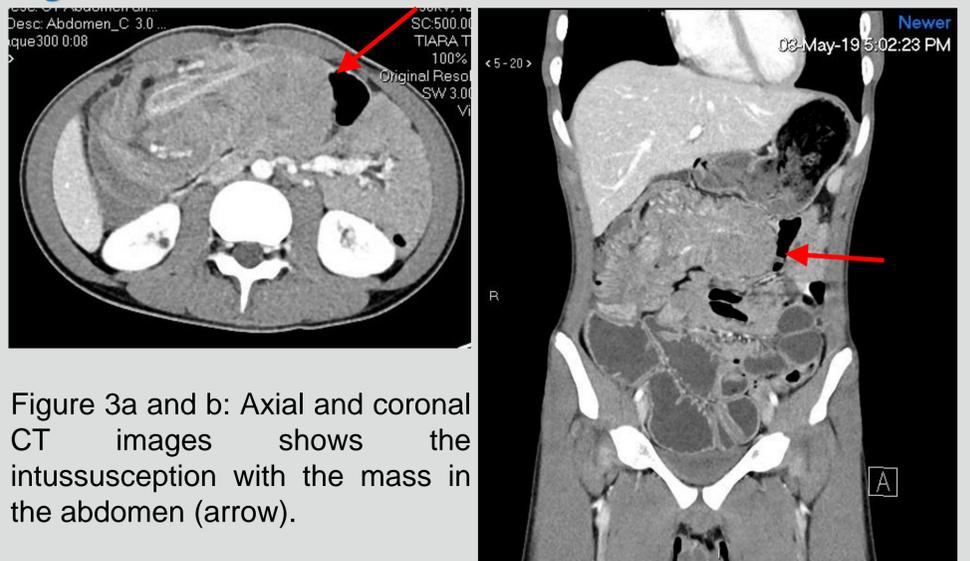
Axial and coronal CT images show the intussusception with the mass in the abdomen (arrow).
